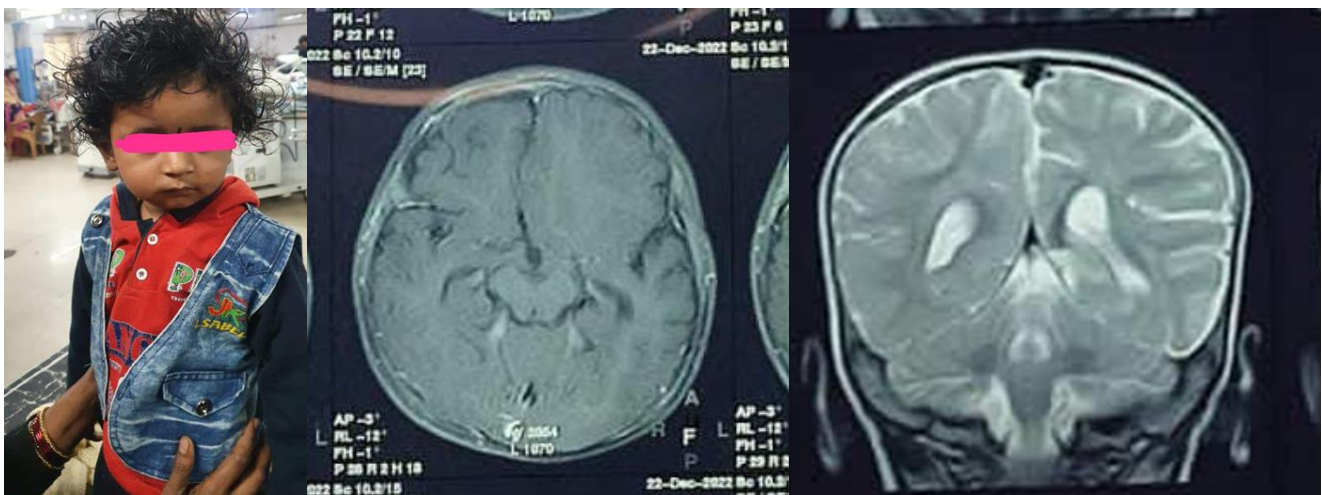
Clinical picture of child and MRI images
